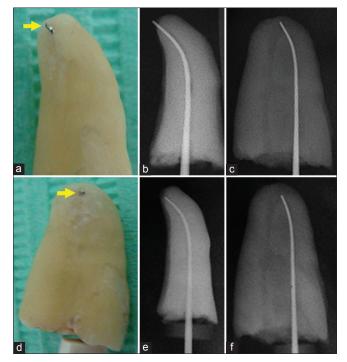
Radiographic interpretation should be augmented with clinical assessment during working length determination. (a-c) An SS hand file adjusted 1 mm beyond the apex (yellow arrow). The over-extension could be detected radiographically if located in a mesio-distal direction (b), but it will appear within the confines of the root if located in a bucco-lingual direction (c). (d-f) Placing the file flushing at the root apex (yellow arrow) could also be misinterpreted as a short working length (f). Therefore, the use of an electronic apex locator is essential
